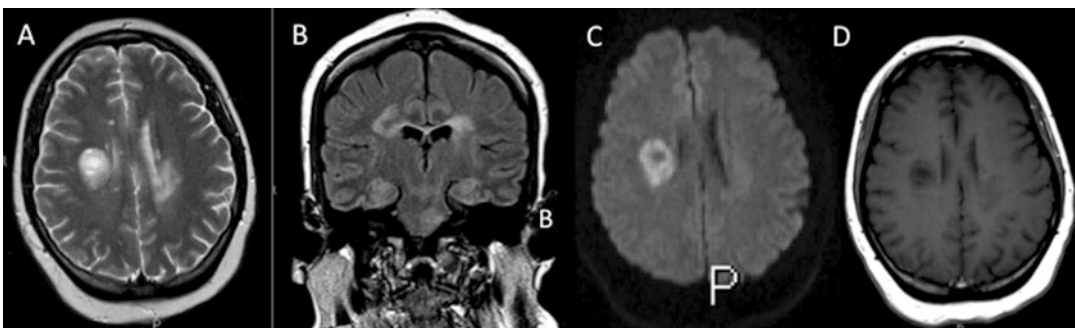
Tumor mimic: tumefactive demyelination T2w (a), T2w-FLAIR (b), b1000 DWI (c), and T1w + Gad (d) images in a young adult female demonstrating a right centrum semiovale mass. On closer inspection, multiple
